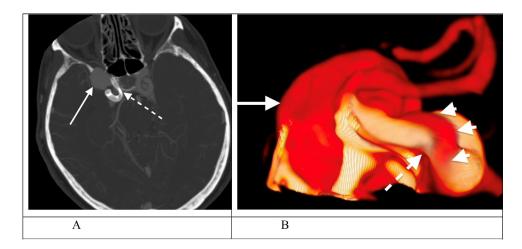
Computed tomography angiography in the arterial phase 5 months after the aneurysm initial exclusion. (A) axial projection, (B) 3D reconstruction. Recurrent aneurysm is indicated by a white solid arrow, non-intraluminal contrast through the pores of the stent is indicated by short white arrows, a collapsed stent is indicated by a white dotted arrow.
